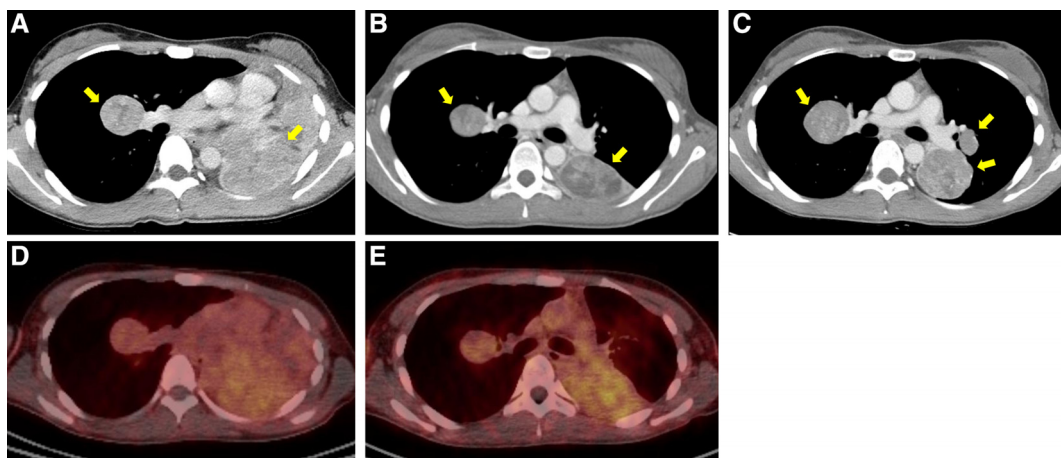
Computed tomography (CT) scan and ^{68}Ga -RGD positron emission tomography-CT scan of patient 3. CT scan before treatment (A), after 2 months of pazopanib treatment (B), and at disease progression (C). ^{68}Ga -RGD PET/CT before treatment (D) and after 14 days of pazopanib treatment (E).
